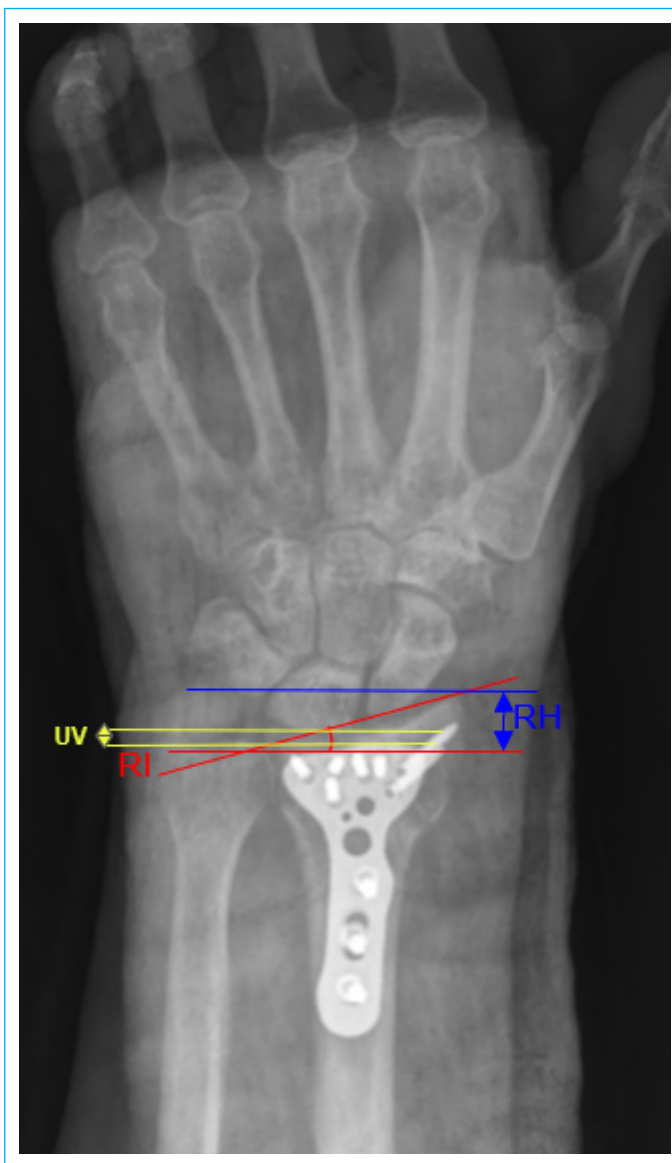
Measurement of radial inclination, radial height, and ulnar variance on the posteroanterior wrist radiograph. RI: radial inclination; RH: radial height; UV: ulnar variance.
